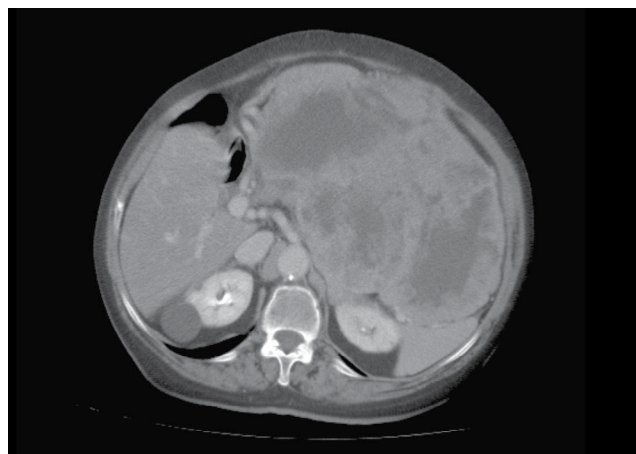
CT scan showing a dishomogenous mass occupying most of the left side of the abdomen.
